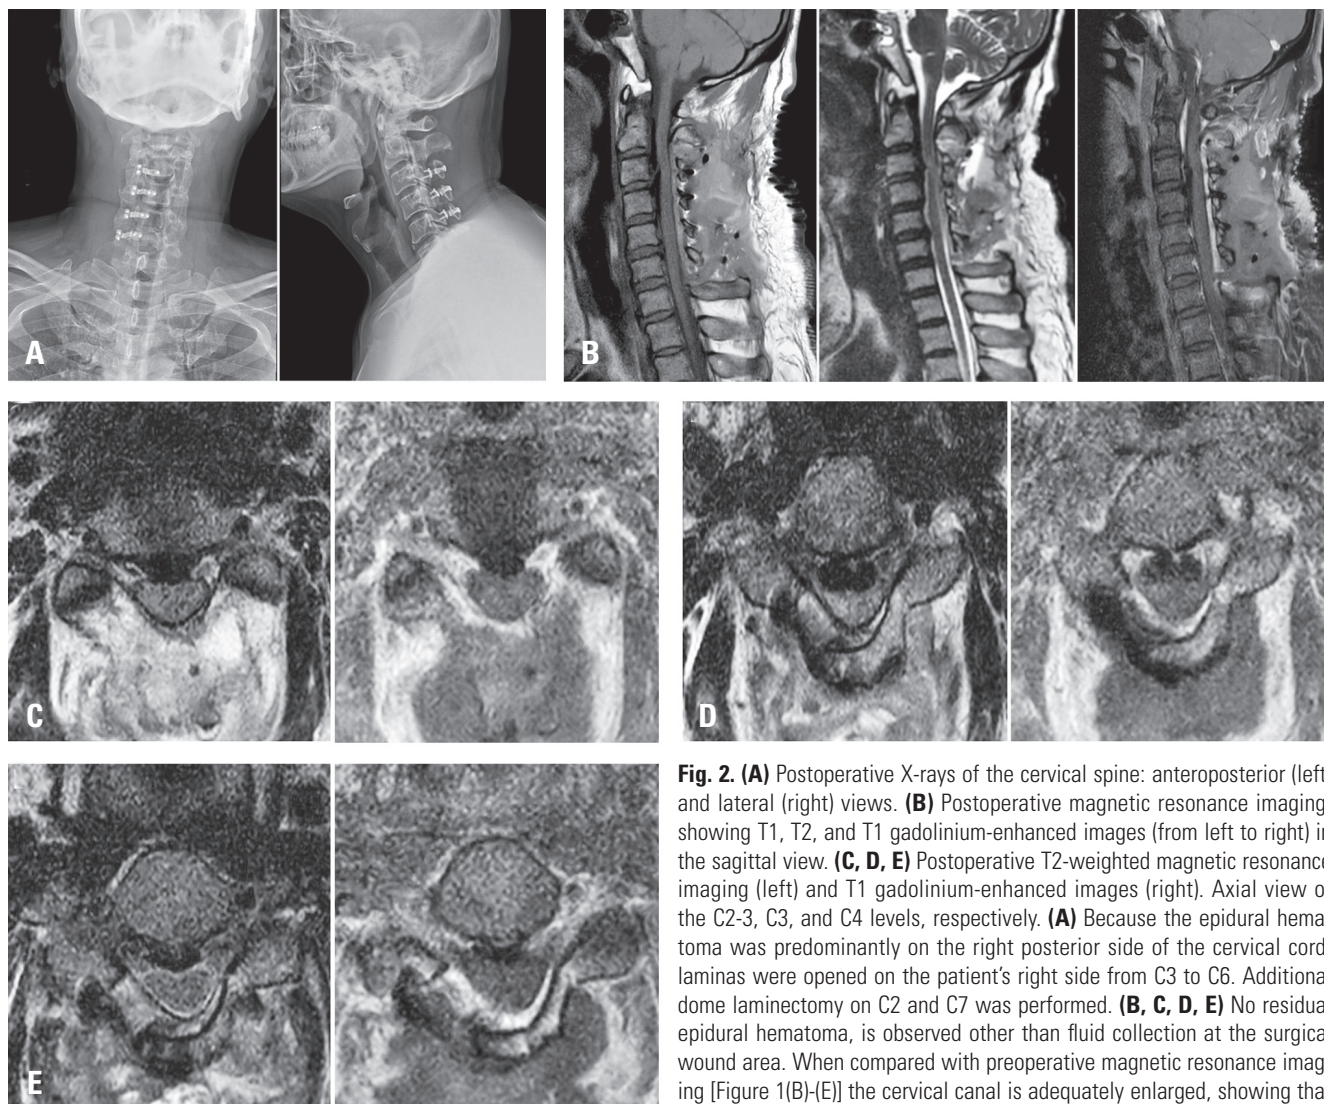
(A) Postoperative X-rays of the cervical spine: anteroposterior (left) and lateral (right) views. (B) Postoperative magnetic resonance imaging, showing T1, T2, and T1 gadolinium-enhanced images (from left to right) in the sagittal view. (C, D, E) Postoperative T2-weighted magnetic resonance imaging (left) and T1 gadolinium-enhanced images (right). Axial view of the C2-3, C3, and C4 levels, respectively. (A) Because the epidural hematoma was predominantly on the right posterior side of the cervical cord, laminas were opened on the patient's right side from C3 to C6. Additional dome laminectomy on C2 and C7 was performed. (B, C, D, E) No residual epidural hematoma, is observed other than fluid collection at the surgical wound area. When compared with preoperative magnetic resonance imaging [Figure 1(B)-(E)] the cervical canal is adequately enlarged, showing that decompression was achieved.
